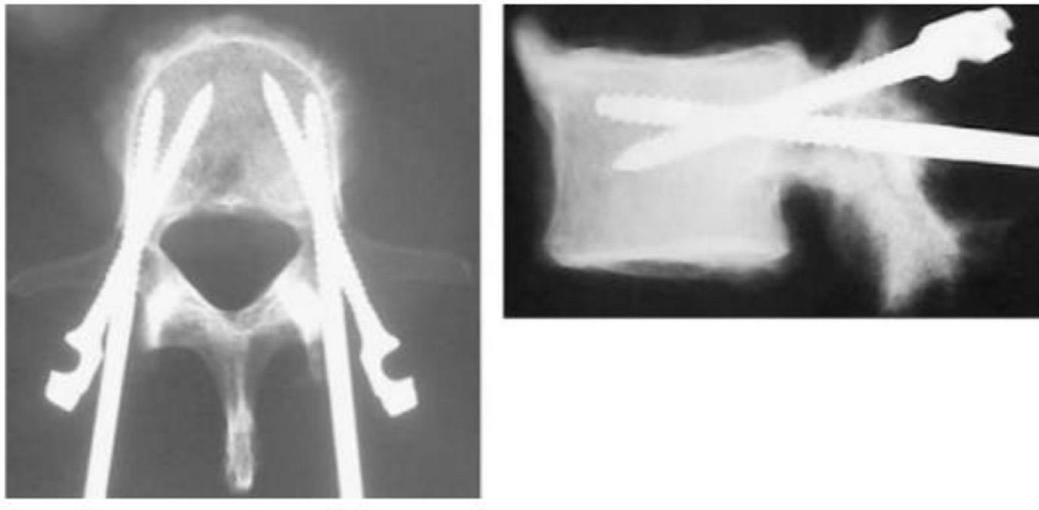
AP and lateral X-ray images of a patient operated by double screw technique of pedicle screw fixation (21).
